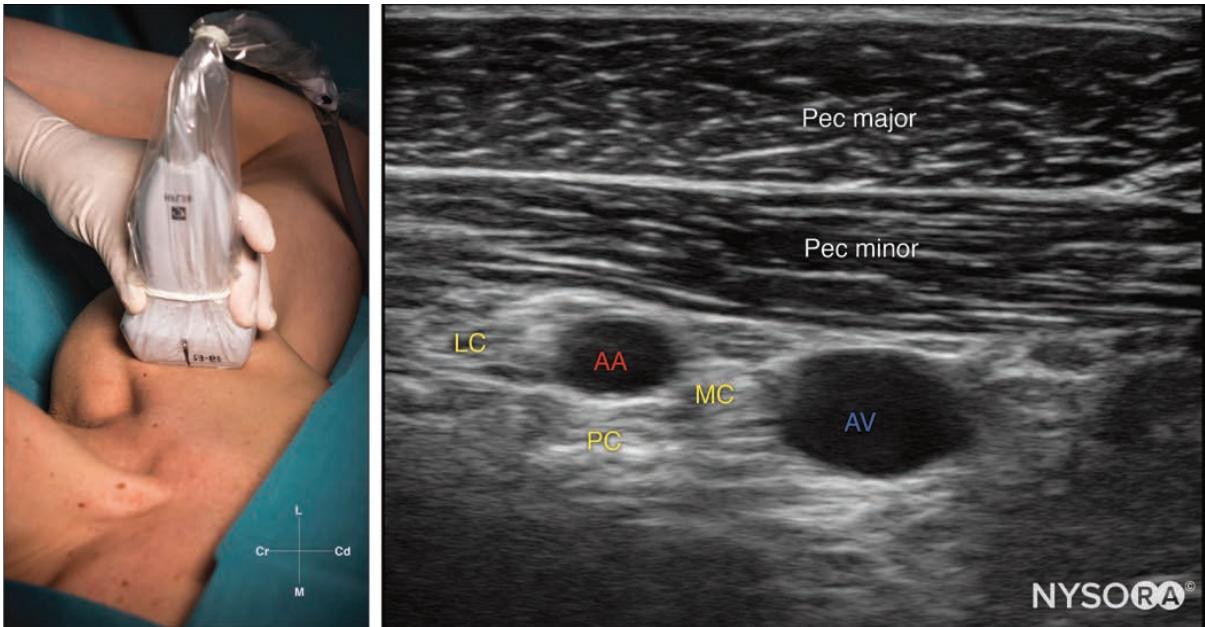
Desired transducer position and ultrasound image. AA, axillary artery; AV, axillary vein; MC, medial cord; LC, lateral cord; PC, posterior cord.
